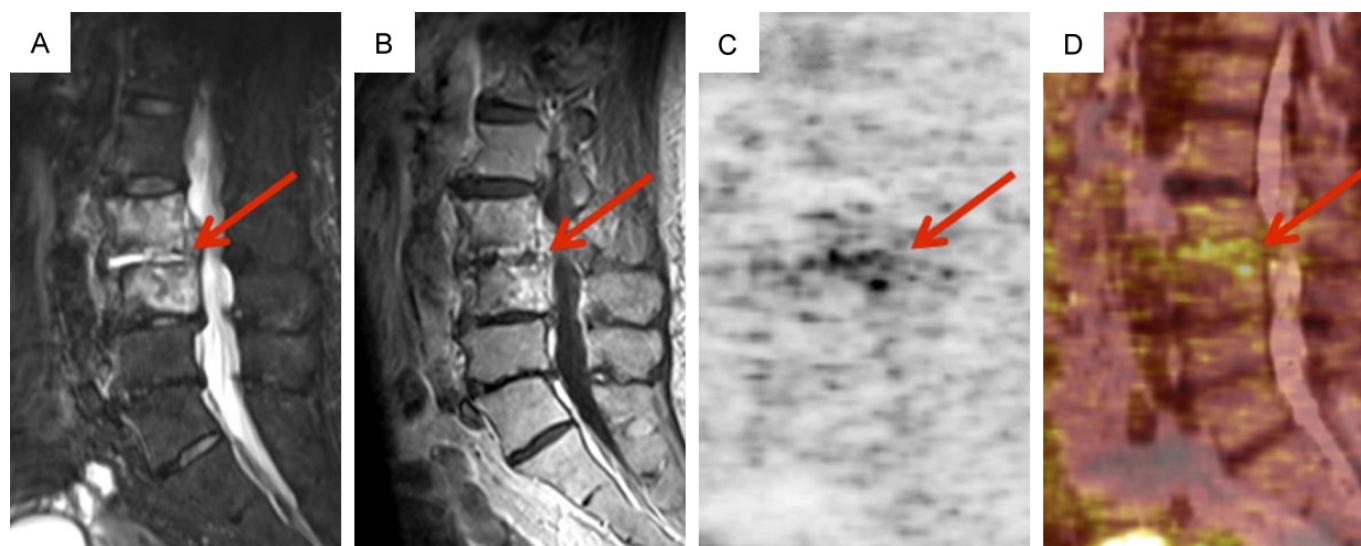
Simultaneous ^{18}F -FDG-PET/MRI in a 71-year-old woman with a final diagnosis of spondylodiscitis after inconclusive MRI. (A) Turbo inversion recovery magnitude (TIRM) shows the typical hyperintense signal at L4-L5 (arrow). (B) T1-weighted MRI shows moderate contrast enhancement (arrow). (C) ^{18}F -FDG-PET and (D) combined ^{18}F -FDG-PET/MRI reveal focally elevated uptake in the affected disc ($\text{SUV}_{\text{max}} = 8.14$, $\text{SUV}_{\text{mean}} = 3.99$), indicating active inflammation. Reproduced from [30] © SNMMI.
